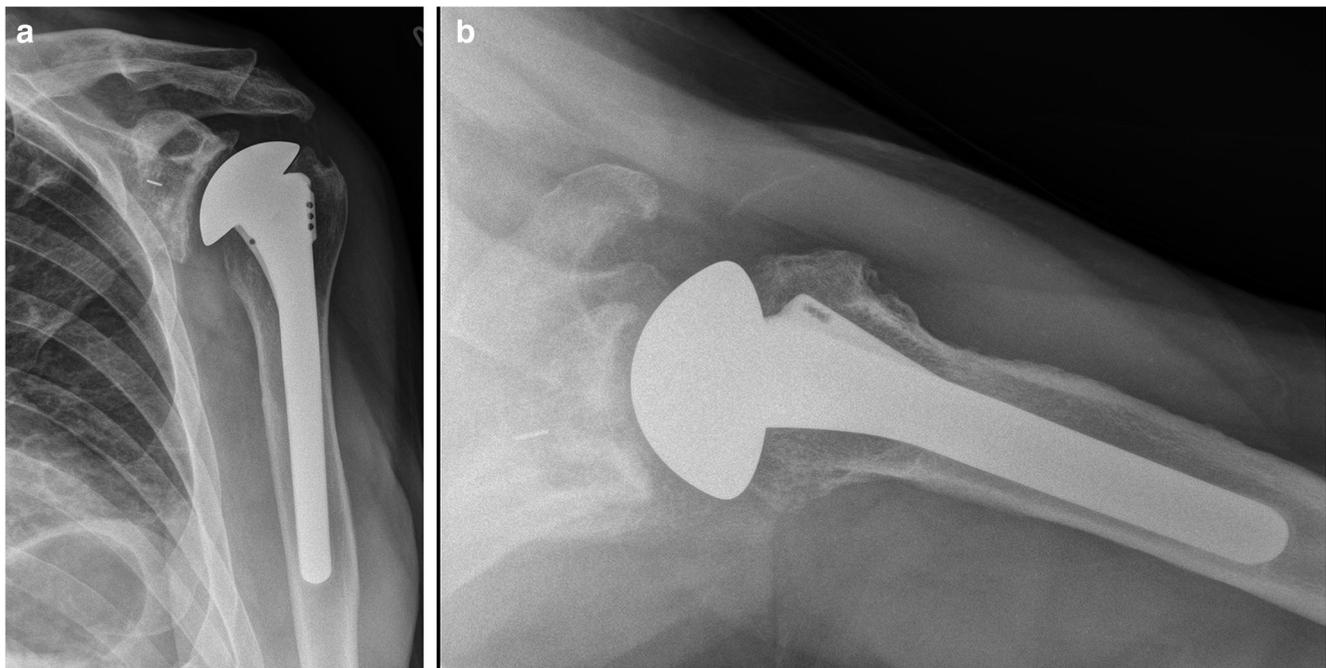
Case 1. a Post-operative AP and b axillary radiographs showing secure fixation of the all-polyethylene glenoid component with bone ingrowth into the fluted central peg (arrow), and the fixation of a smooth stemmed humeral component with impaction autografting
